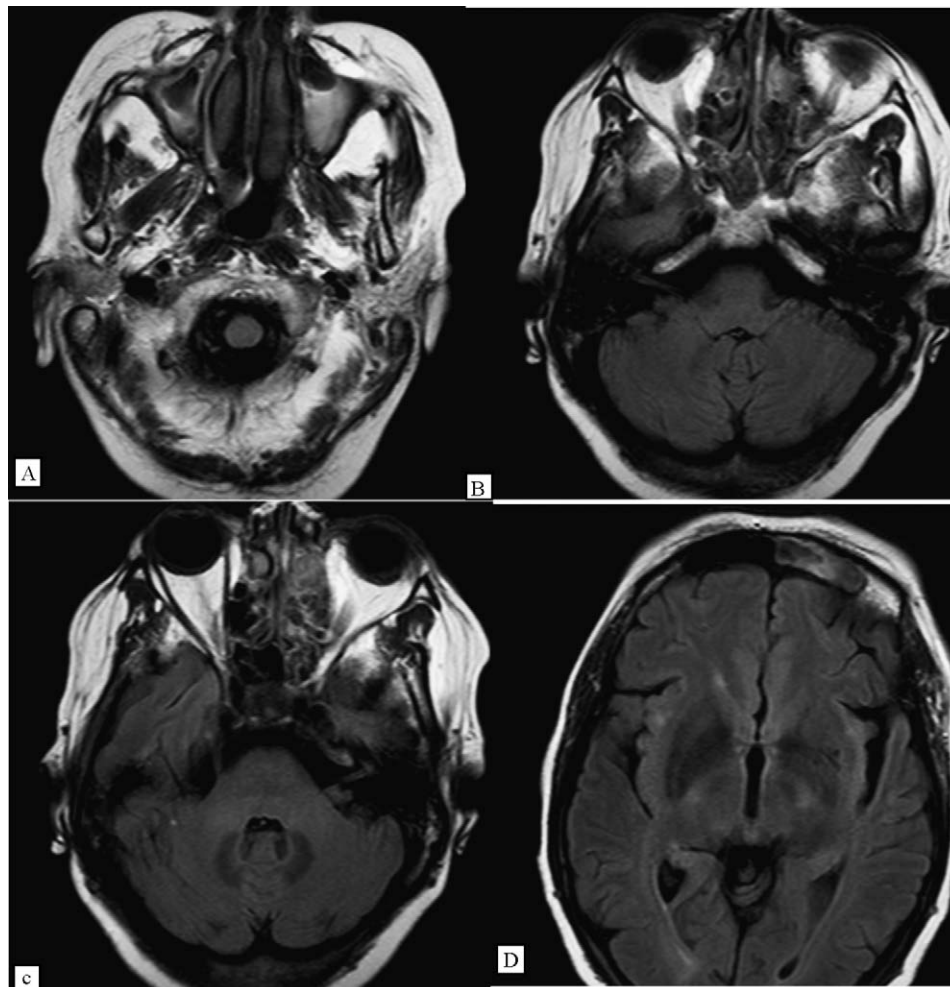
Magnetic resonance images showing evidence of mucosal thickening of the ethmoidal (A–C) and frontal (D) sinuses.
